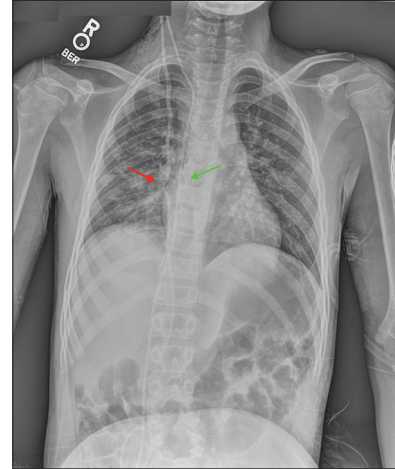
X-ray shunt series completed on postoperative day 1 after the initial revision at 11 years of age and 1 year before distal shunt catheter migration. Chest and abdominal AP X-ray shunt series demonstrated peritoneal VP shunt catheter disconnection. The abandoned system on the right (red arrow) represents the old, disconnected shunt catheter while the distal catheter on the left (green arrow) represents the newly inserted peritoneal shunt system.
